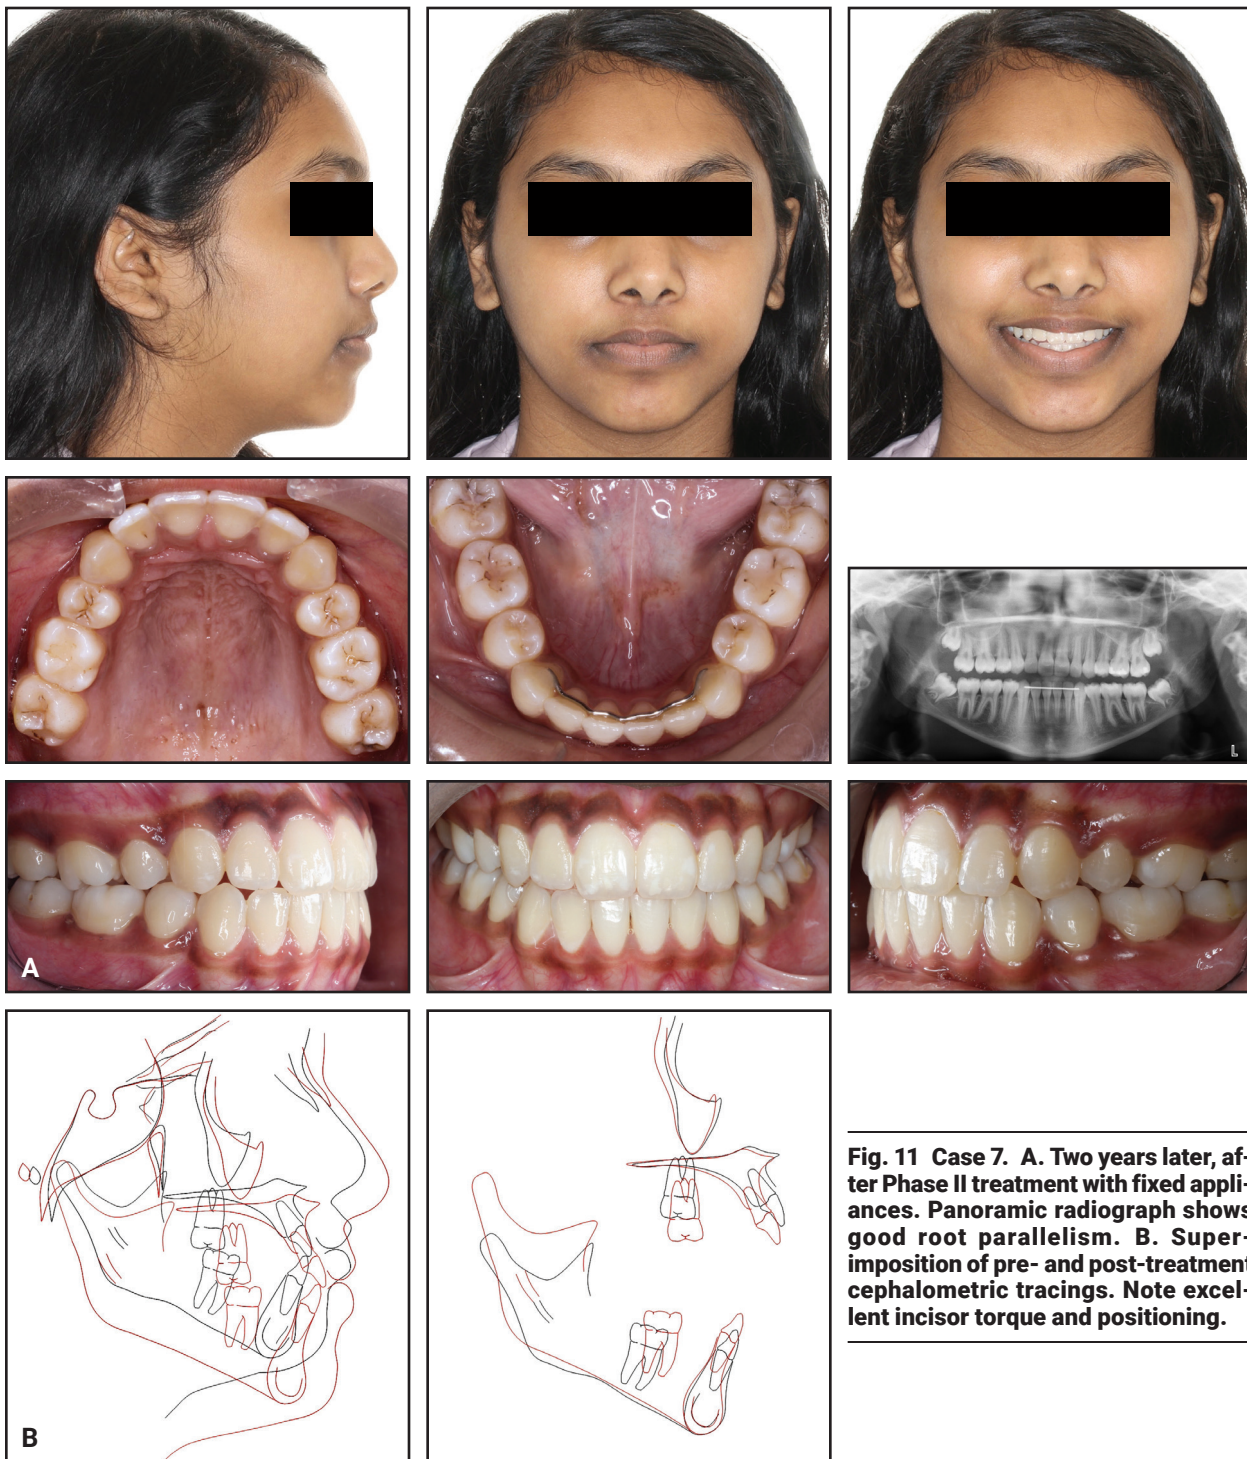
Case 7. A. Two years later, after Phase II treatment with fixed appliances. Panoramic radiograph shows good root parallelism. B. Superimposition of pre- and post-treatment cephalometric tracings. Note excellent incisor torque and positioning.
